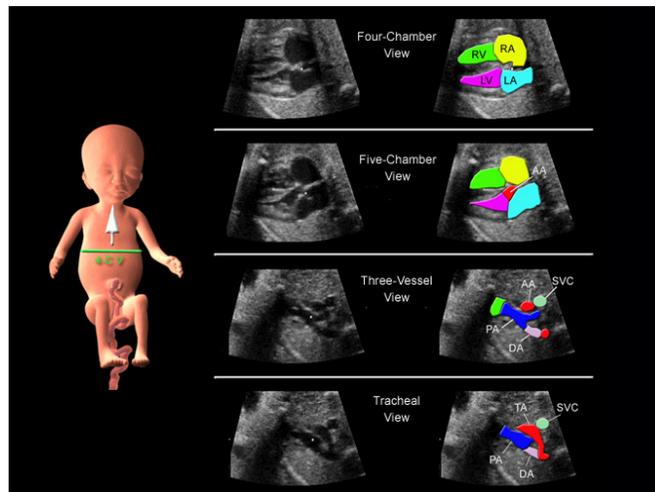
The views can be obtained by directing the ultrasound beam from the four-chamber view to the upper thorax in a transverse plane. The views that are observed in sequential order are the four-chamber view, the five-chamber view, the three-vessel view, and the tracheal view. If all of these views are normal, then major congenital heart defects can be eliminated. RA=right atrium, LA=left atrium, RV=right ventricle, LV=left ventricle, AA=ascending aorta, PA=pulmonary artery, SVC=superior vena cava, DA=ductus arteriosus, TA=transverse aortic arch.
